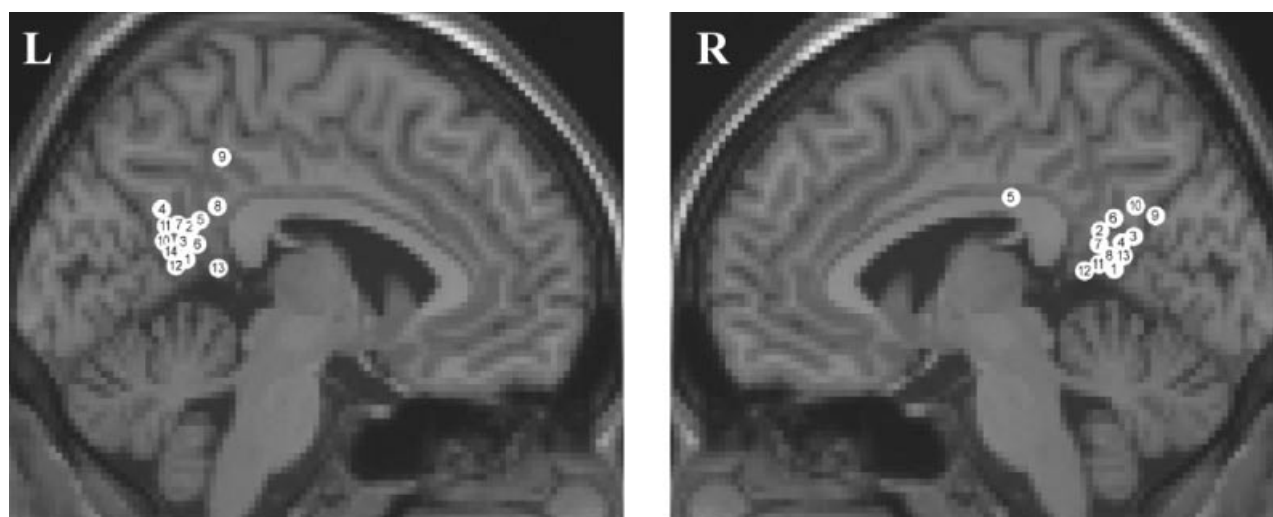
The approximate locations of the main peak activations from the studies listed on Table 2 (see superscripts attached to coordinates for key), shown on a structural MRI scan in stereotactic space (see caveats in the text). While the Talairach and Tournoux (1988) coordinate system is used, their atlas was not, as labelling of the retrosplenial area is not correct (see Vogt *et al.*, 2000). The locations were labelled with reference to Brodmann (1909) and Duvernoy (1999).
